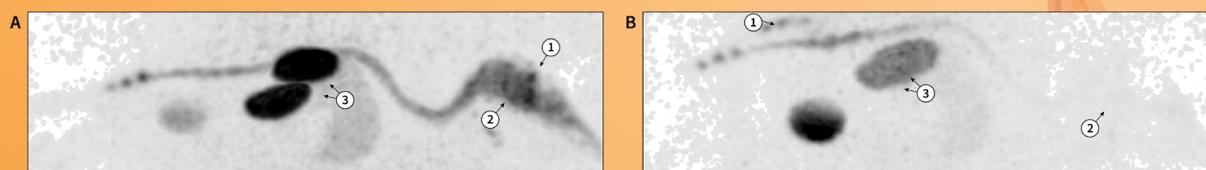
Sagittal summary of SPECT signal four hours after a) intracerebroventricular and b) intrathecal injection with indium-111 labelled APP AON. Both injections show a spread throughout the body away from the injection-site (1). Intracerebroventricular injection shows a higher signal in the brain (2). The majority of the signal is in the kidneys (3) at this time-point.
